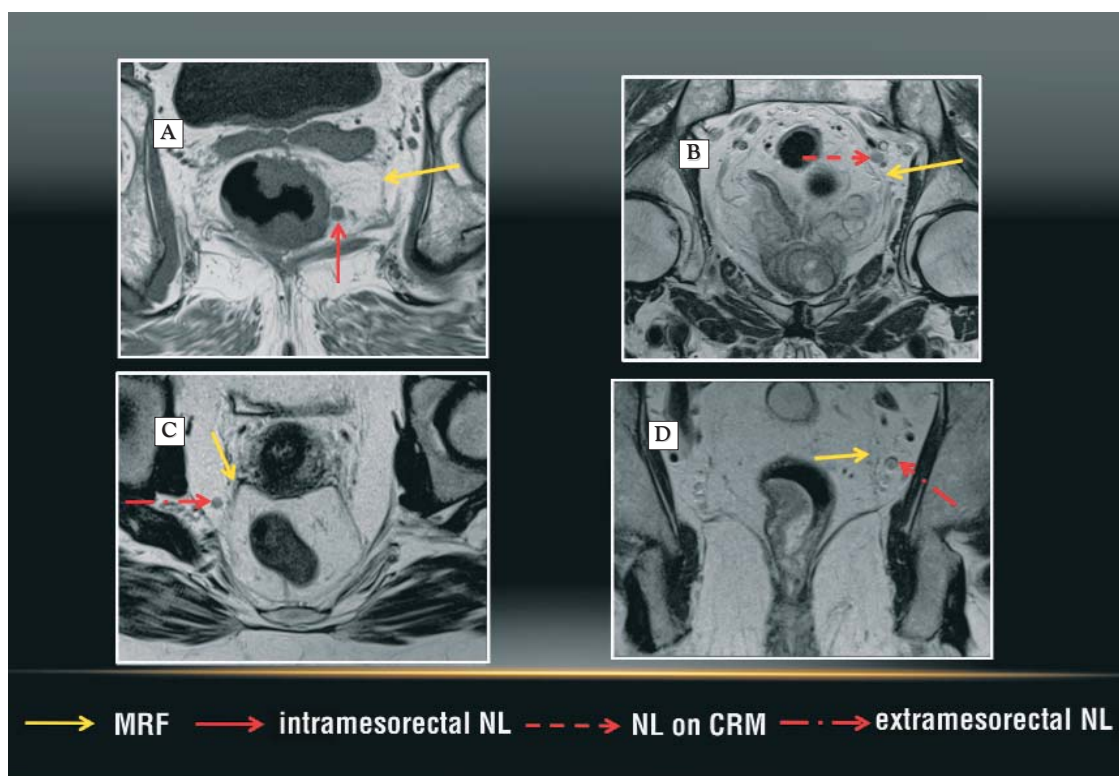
Lymph node localization using MRI
